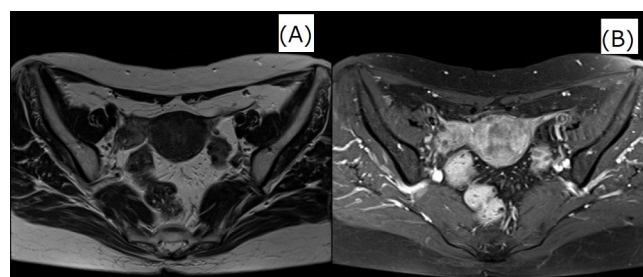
Images obtained after 6 months of the treatment. MRI and transvaginal ultrasonography revealed shrinkage of right adnexal mass. (A)MRI T2-weighted image and (B)MRI fat suppression gadolinium contrast T1-weighted image.
